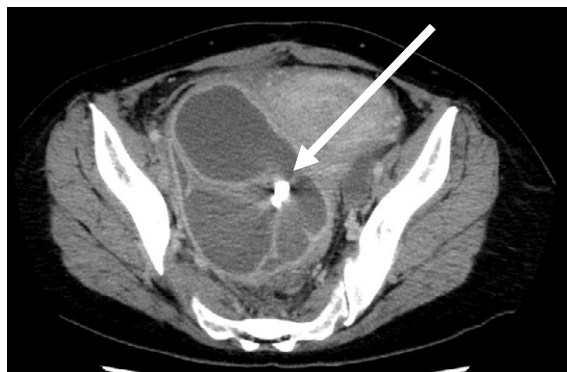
Computed tomography scan of the pelvis showing the fluid-containing right adnexal cyst, suggestive of an abscess. The arrow indicates the inserted catheter.
